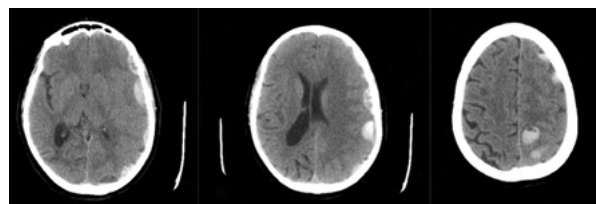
Case 2: Axial CT images imaging showing multiple haemorrhagic lesions in the left hemicranium with predominant subarachnoid distribution and mass effect
